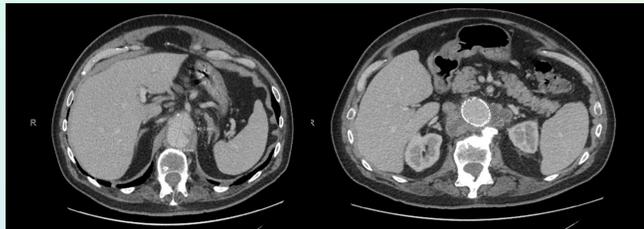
This CT scan demonstrates the saccular aneurysm at the aortic hiatus measuring 5.5x4.1 cm. The patient had previously undergone stent grafting also seen in the image.
